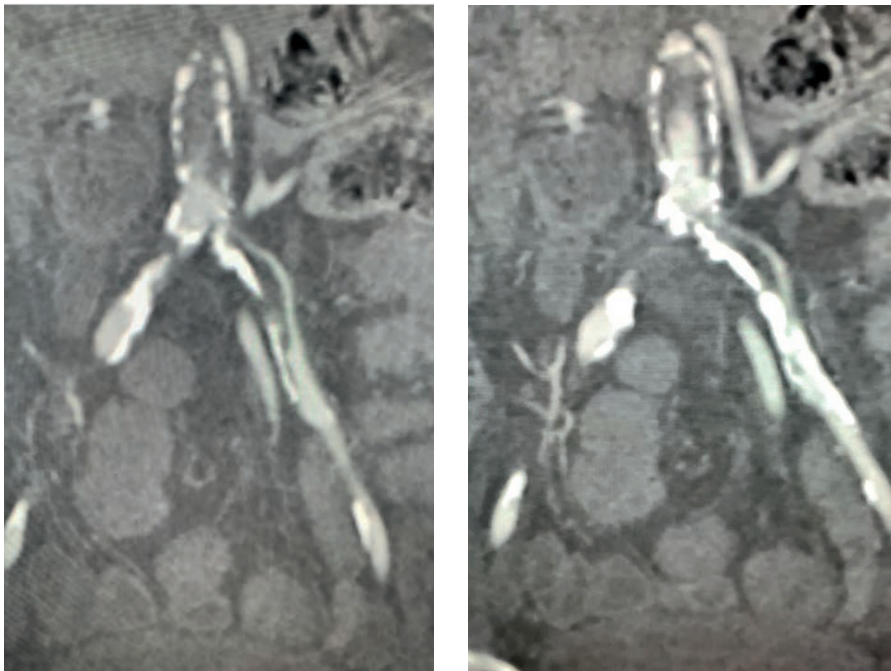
CT angiography coronal reconstruction showing severe osteal stenosis at right common iliac and total occlusion of the left common iliac artery with extensive calcification on the left side.
